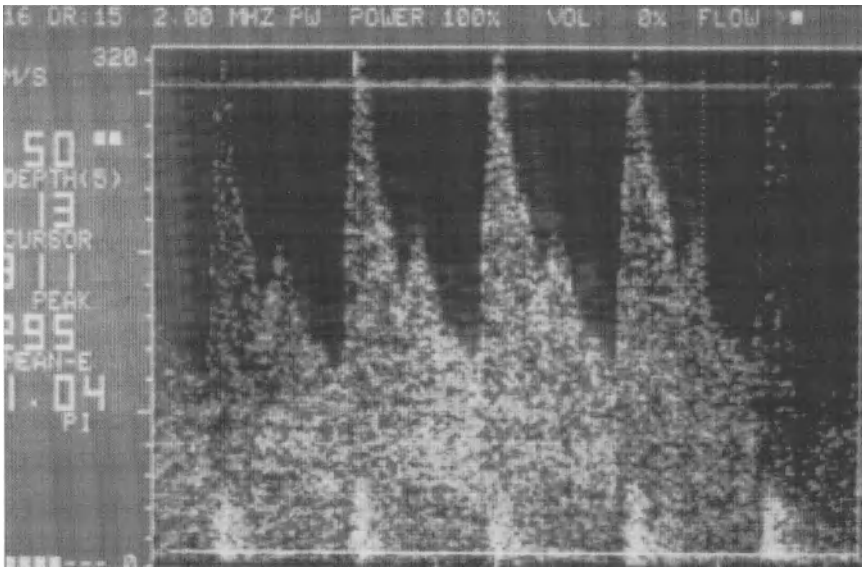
Doppler trace with very high flow velocity
